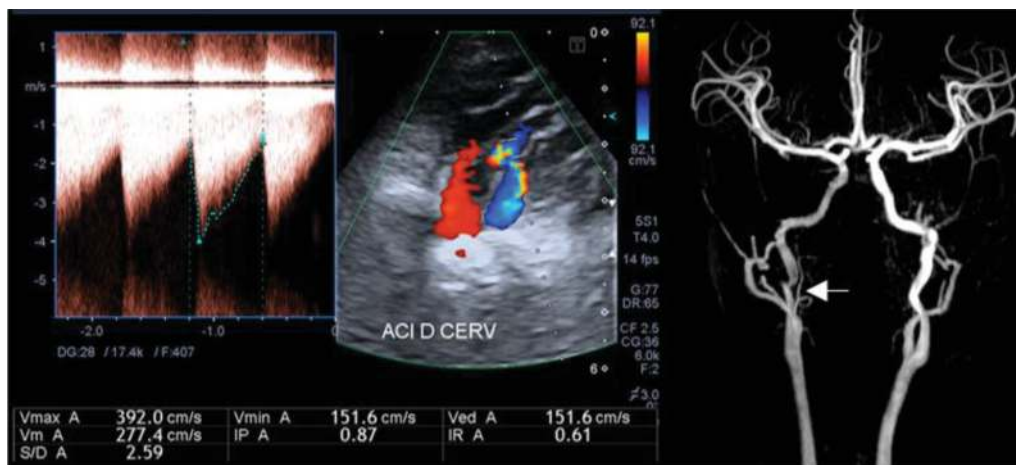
Six-year-old boy without history of stroke. Routine Doppler ultrasound detected focal acceleration in the middle part of the right cervical ICA with TAMV 277 cm/s. 3D TOF MRA shows focal marked narrowing of the artery associated with a kink. Notice the hypointensity of the right ICA due to poor flow.
